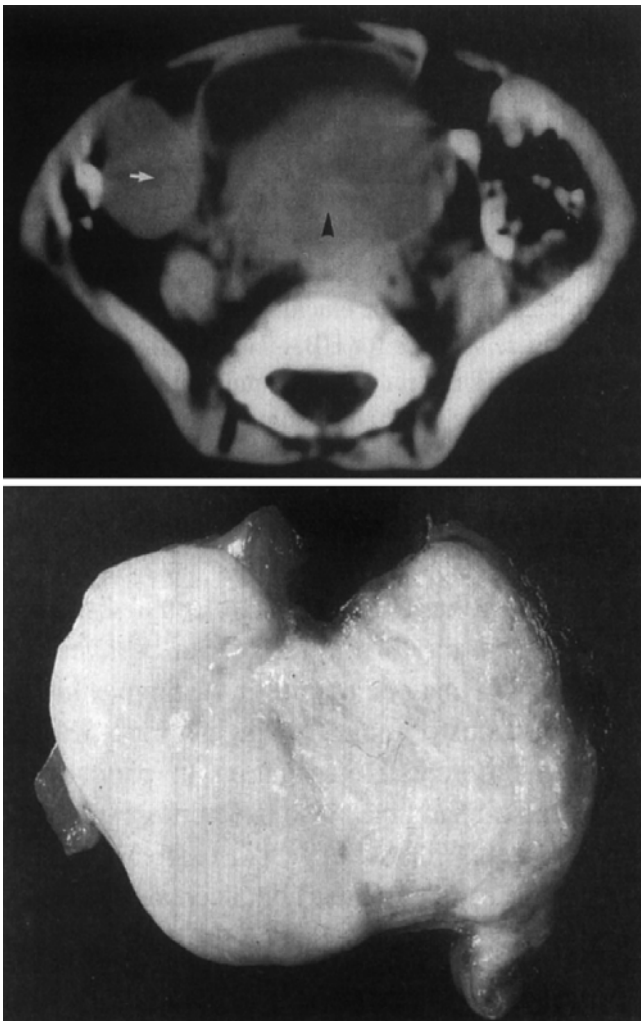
Ectomesenchymoma. Upper picture shows CT-scan with different components (*black and white arrows*), lower picture show cut surface with different differentiations (from Hajivassiliou, Figs. 1 and 3)
